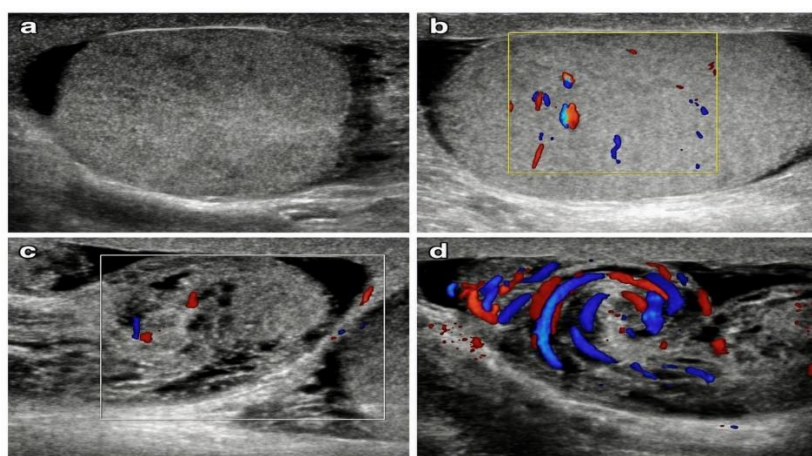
A 22-year-old man presenting with sudden-onset severe right scrotal pain that was not relieved by medication. (a) B-mode ultrasonography showing heterogeneous echotexture of the right testis. (b) Colour Doppler image showing altered intratesticular vascularity. (c) B-mode and Colour Doppler image showing a bulky, heterogeneous spermatic cord and epididymis. (d) Colour Doppler image demonstrating the whirlpool sign within the twisted spermatic cord, suggestive of testicular torsion.
